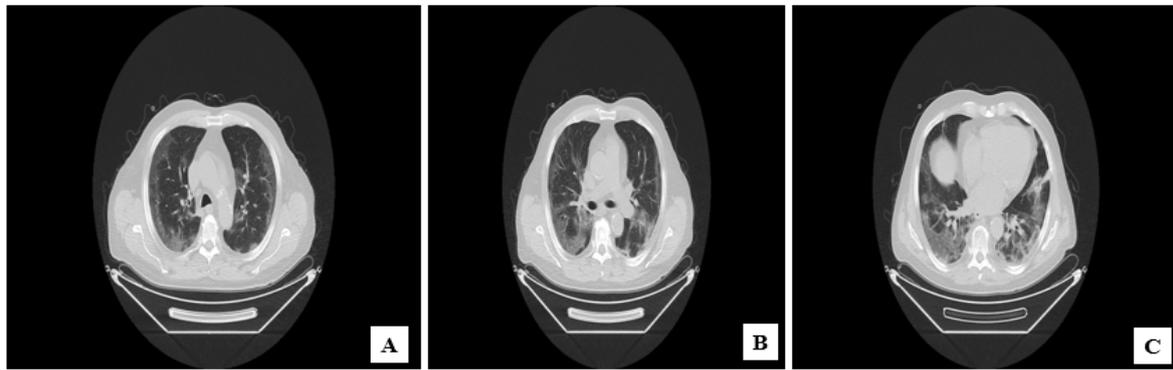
Images shown are chest high-resolution computed tomography obtained on first day (A), day7 (B), day 12 (C) of illness.
